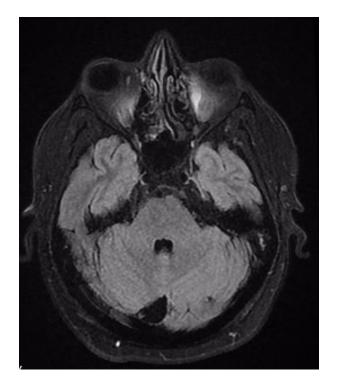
T2 MRI of the brain, axial view. After receiving the treatment course.
